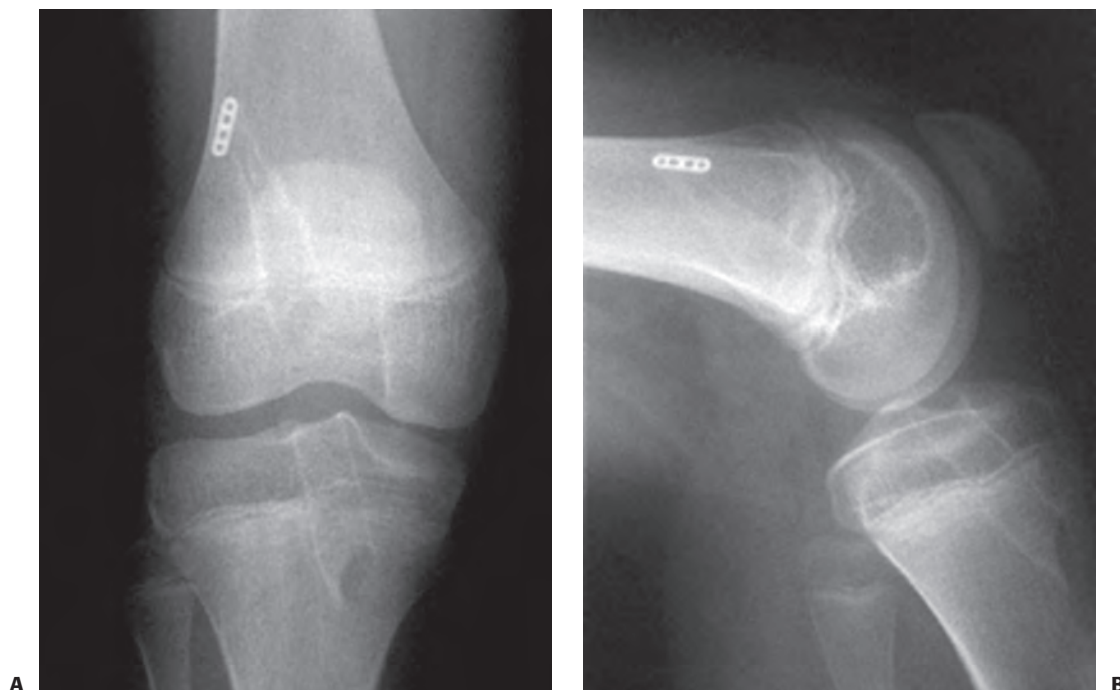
Transphyseal reconstruction with autogenous hamstrings for adolescents with growth remaining. Postoperative anteroposterior (A) and lateral (B) radiographs.
